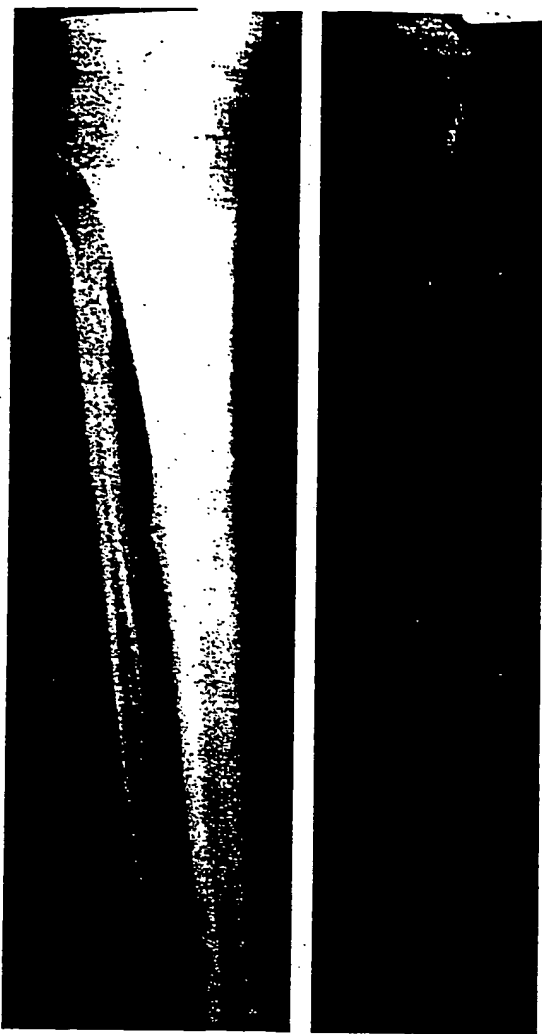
AP and lateral radiographs showing the stress fracture of the anterior midshaft of the tibia.
